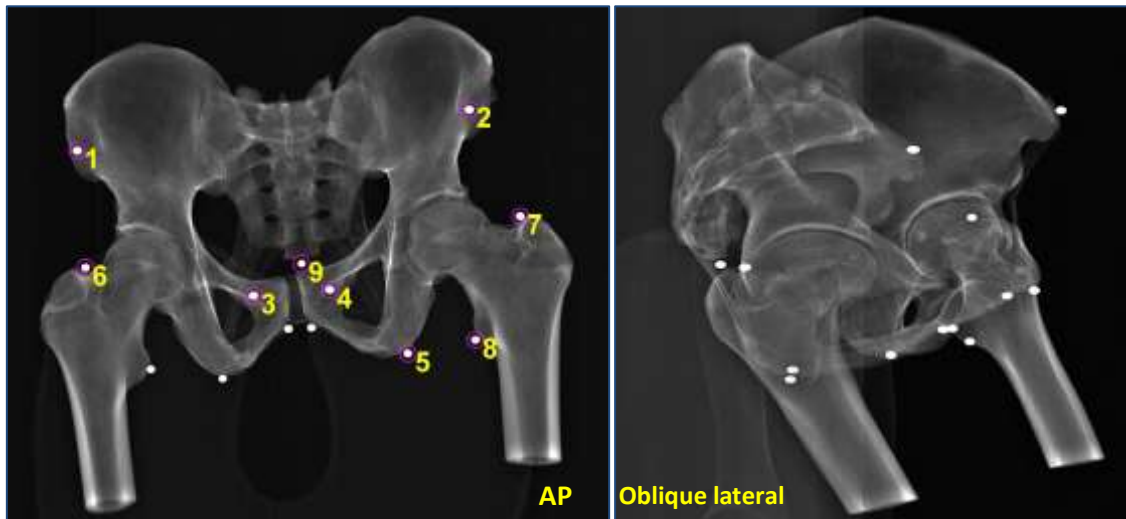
Antero-posterior and oblique lateral X-ray images of the pelvis used for ILD and ILA measurement.
